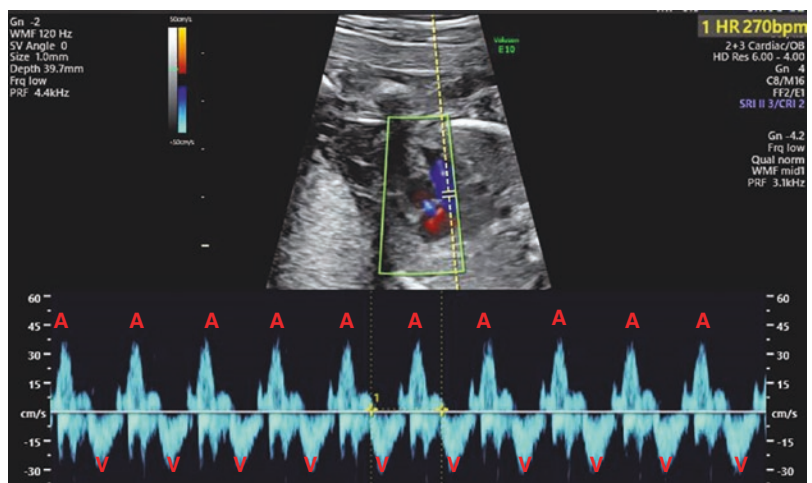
SVC–aorta Doppler of SVT from the same patient
